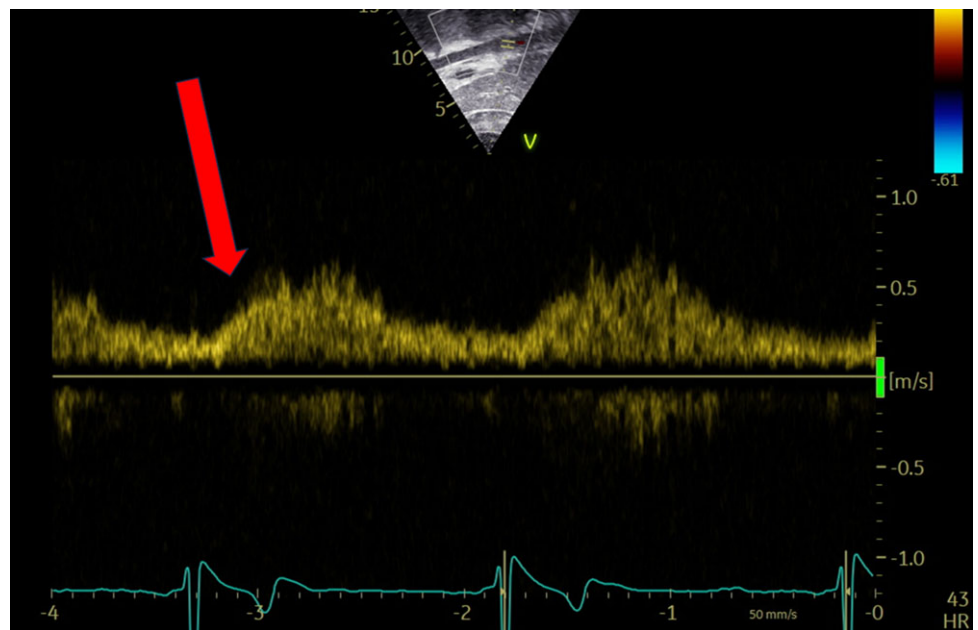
Doppler profile of the abdominal aorta: continuous abdominal aortic flow (red arrow).
